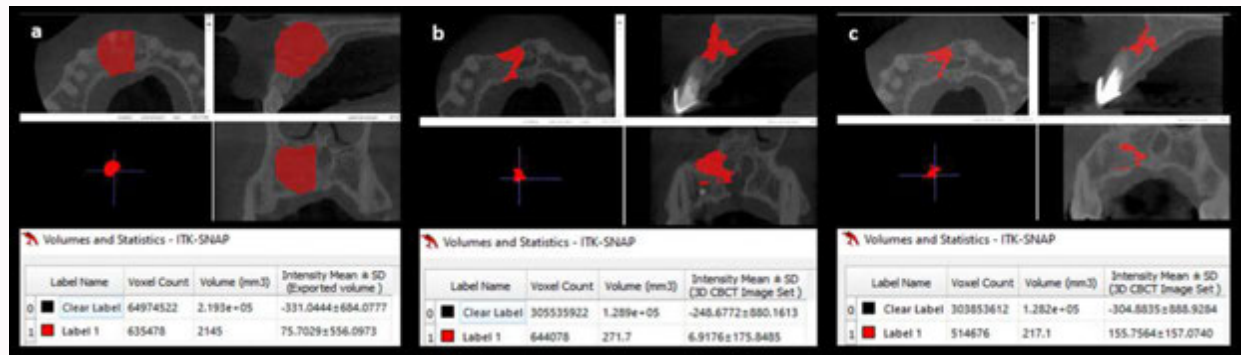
Case 1. a) Pre-operative CBCT Volumetric analysis using ITK-SNAP Software, b) First follow-up CBCT Volumetric analysis using ITK-SNAP Software, c) Second follow-up CBCT Volumetric analysis using ITK-SNAP Software.
